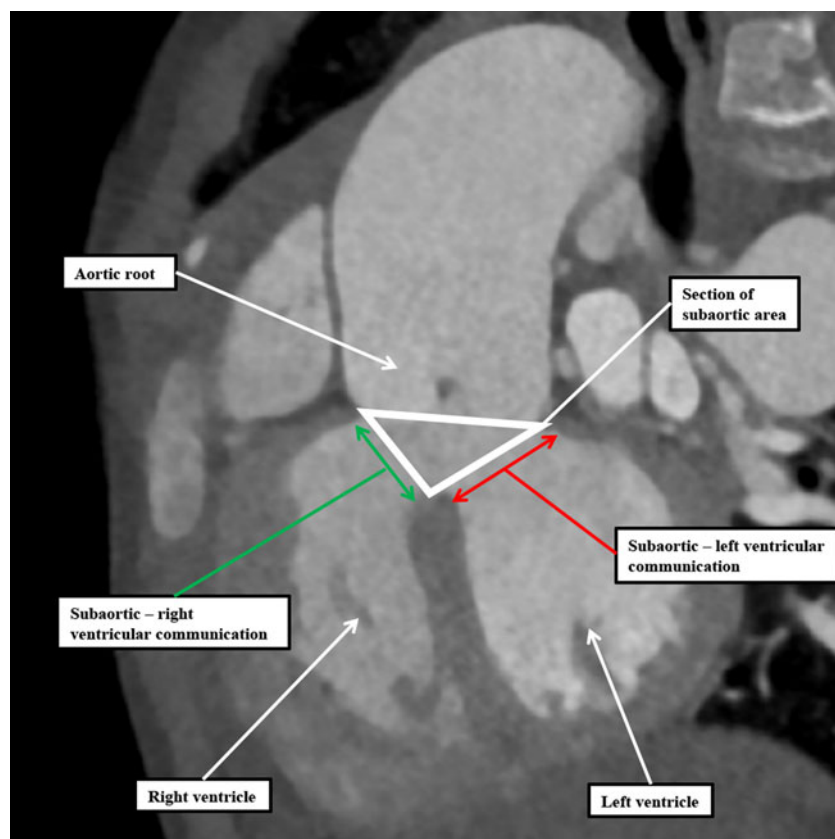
The figure shows a section from a computed tomographic dataset prepared from a patient having tetralogy of Fallot with concordant ventriculo-arterial connections. It is possible to construct a triangle within the area subtended beneath the overriding aortic root. The sides of that triangle represent communications between the area subtended beneath the root and the cavities of the right and left ventricles. It is currently the communication with the right ventricle, shown by the double-headed green arrow, that is named as the “ventricular septal defect.” This space would be closed by the surgeon during operative repair.
